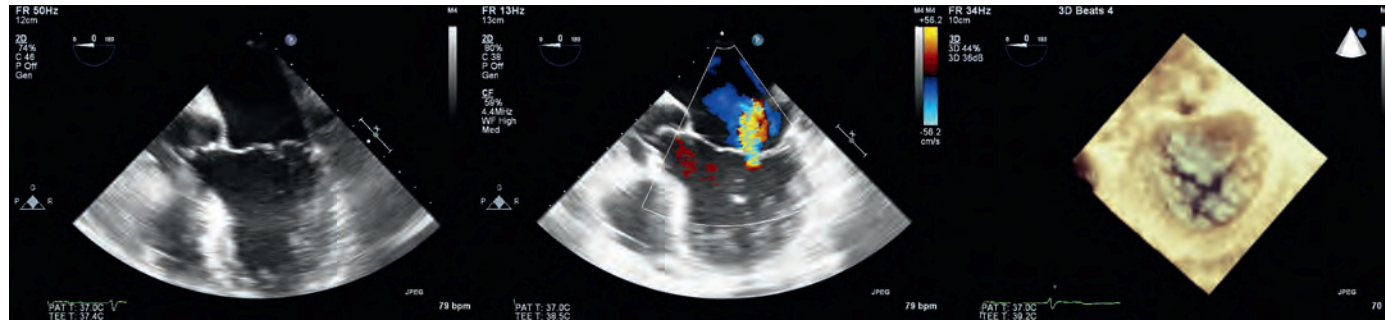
Mitral regurgitation Type I. (Left and center) Midesophageal five-chamber view reveals the anterior and posterior leaflets coapt at the level of the mitral valve annulus, but the space between the two leaflets is significant. (Center) Application of color-flow Doppler reveals a central jet. (Right) In addition to the poor coaptation of the anterior and posterior leaflet, this three-dimensional reconstruction visualizes a large cleft in the posterior leaflet, which contributes to the regurgitation. (Video available online.)
